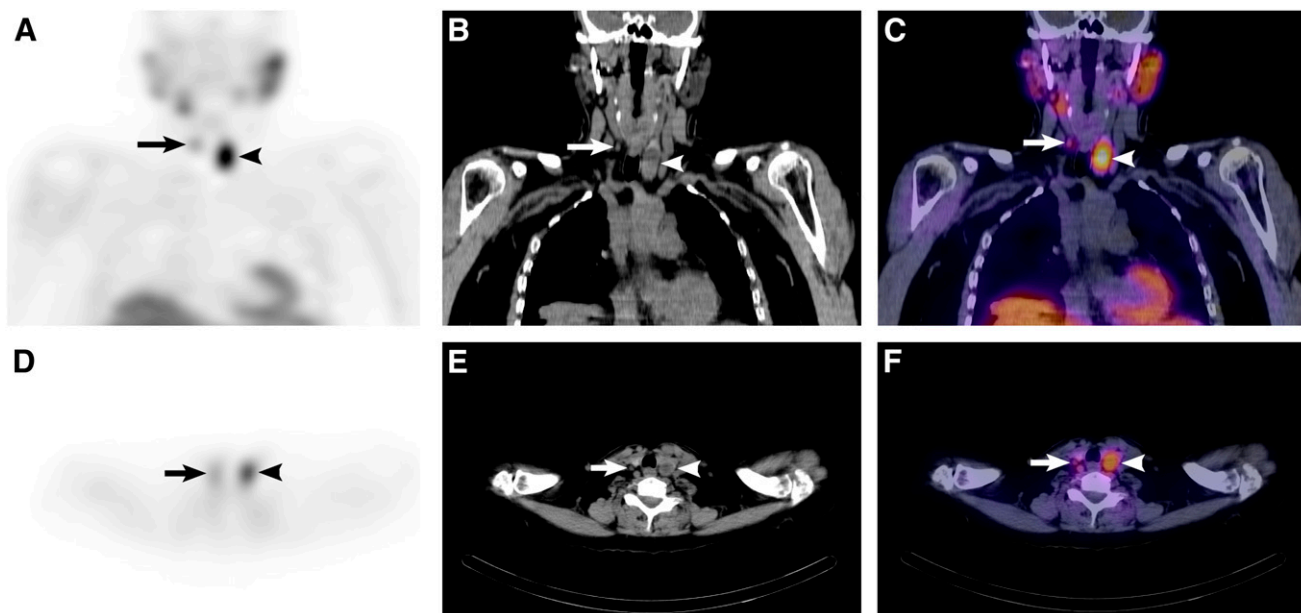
Scans performed on 64-y-old woman with primary hyperparathyroidism. Selected coronal (A–C) and transverse (D–F) tomograms of subtraction SPECT (A and D), CT (B and E), and fused SPECT/CT (C and F) demonstrate focus of residual activity associated with small soft-tissue nodule (arrow) located posterior to right thyroid lobe, found at surgery to represent 150-mg parathyroid adenoma. Larger, more intense site of residual activity associated with 3-cm nodule within left thyroid lobe (arrowhead) was found at surgery to represent 5-g well-encapsulated thyroid adenoma.
